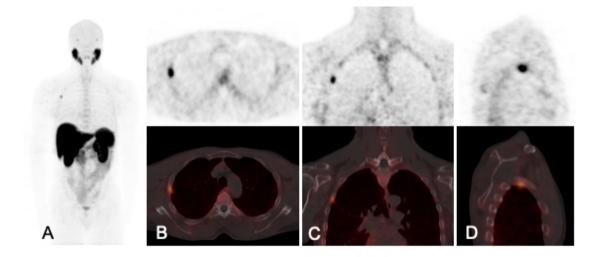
60 year old male with prostate cancer, Gleason3+3, presenting with history of rising PSA (0.33ng/ml). His treatment history included radical prostatectomy with clear margins. No further therapy has been given. ¹⁸F-PSMA-1007 PET/CT study was performed for suspected biochemical recurrence. The MIP image (A) demonstrated uptake that localized to the rib lesion. on the CT, PET/CT PET and fused axial, coronal and sagittal images (B-D respectively). Prostate specific membrane antigen (PSMA) is a type II membrane antigen with high expression in prostate cancer cells resulting in increasing interest in its targeting with PSMA ligands in prostate cancer imaging ^{1,2}. ¹⁸F-PSMA-1007 has demonstrated great sensitivity and specificity in its ability to detect prostate cancer metastases even at low PSA levels ³. The PSMA molecule is not only overexpressed in prostate cancer but may also be overexpressed in other cancers and benign conditions leading to interpretation errors ⁴⁻⁶.
